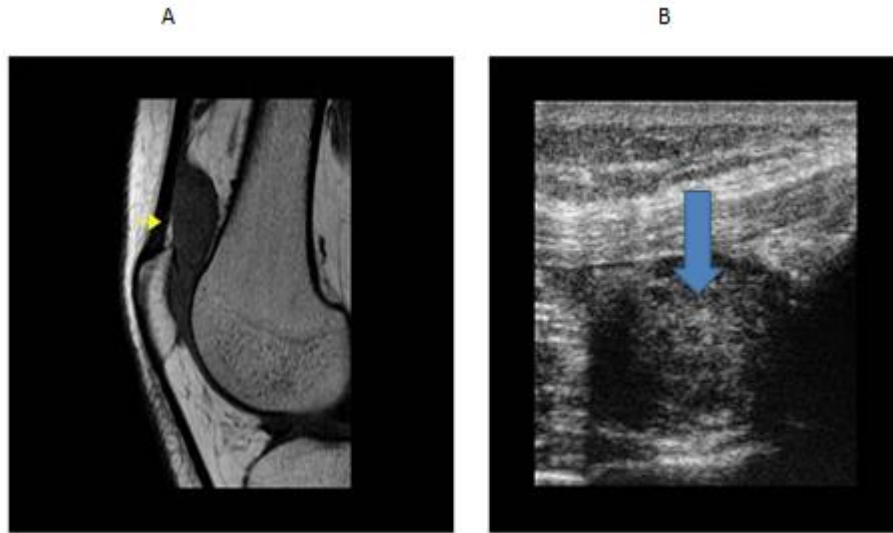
Knee joint Soft tissue mass in continuation with the suprapatellar recess, Sagittal T1 weighted Magnetic Resonance Imaging (MRI):A, without effusion and synovial thickening in Ultrasound B
